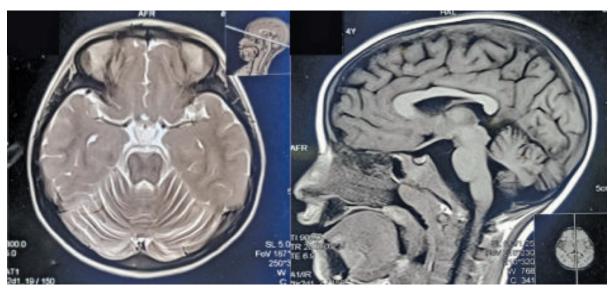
MRI of brain showing atrophy of cerebellum and cerebrum in a case of PME
